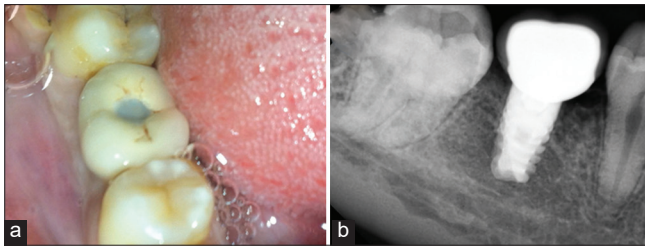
Four years post-operative of reimplantation (a) intraoral image, (b) intraoral periapical
